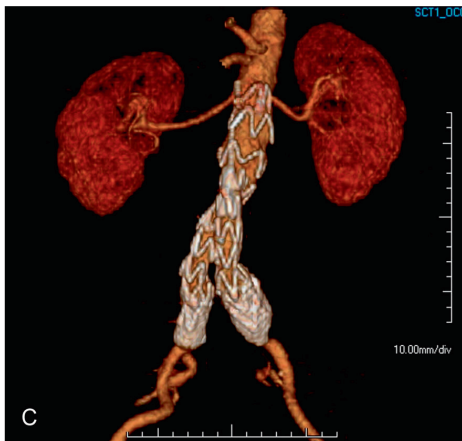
3-dimensional surface reconstruction of CT angiogram.
